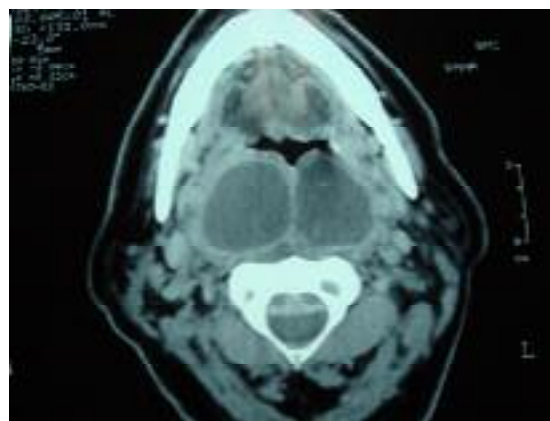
Axial CT scan shows abscess and calcification in the abscess and destruction of vertebral body (vertebral osteolysis).
